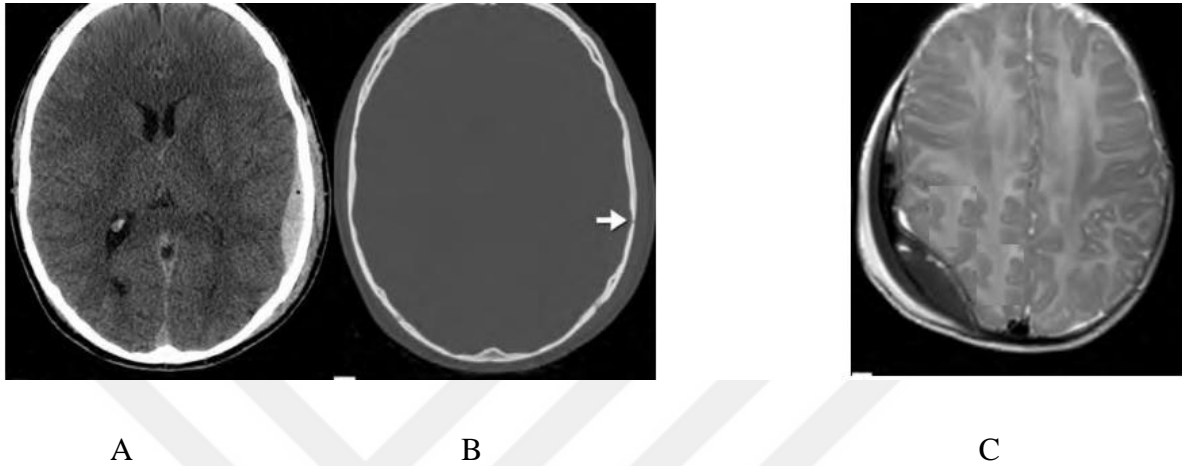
(A, B) CT scans showing classic biconvex hyperdense epidural hematoma with an overlying nondisplaced calvarial fracture (arrow). (C) MR of different patients (3-month-old accidentally dropped on her head) reveal a right parietal biconvex low signal epidural collection.
